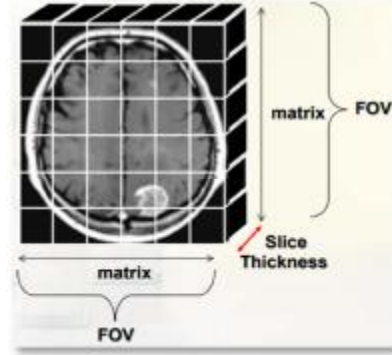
Definition of FOV, matrix size, and slice thickness on MRI image (web5, 2018)
